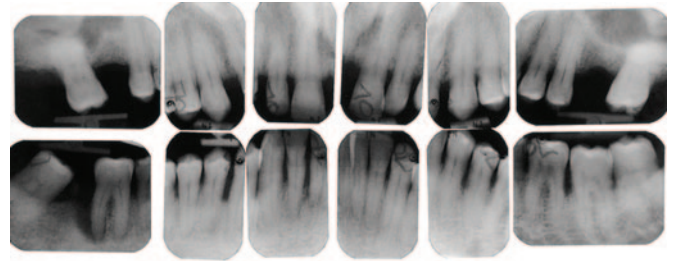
Furcation involvement was identifiable clinically and radiographically on multiple teeth.
